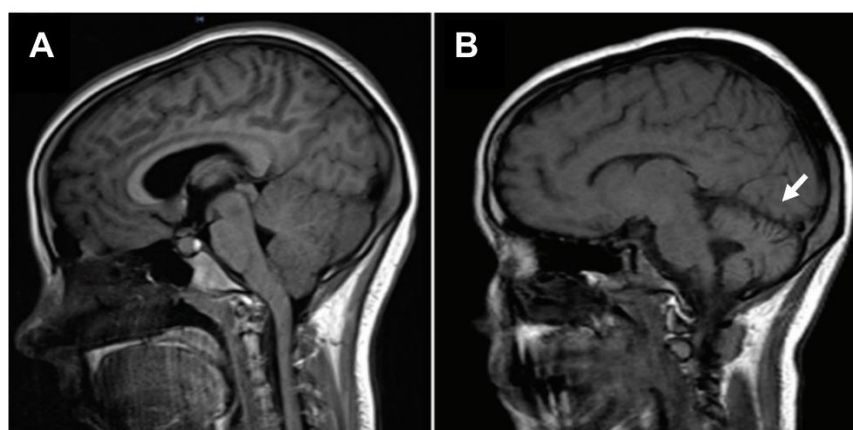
Brain magnetic resonance imaging (MRI) showing progressive cerebellar atrophy. In a female Caucasian diagnosed with autoimmune anti-glutamic acid decarboxylase (GAD) associated cerebellar ataxia was acquired brain MRI, sagittal view, T1-weighted image obtained at (A) the disease onset and (B) follow-up at 6 months. Adapted from Gomez, J. and Jin, D. (2019)³.
